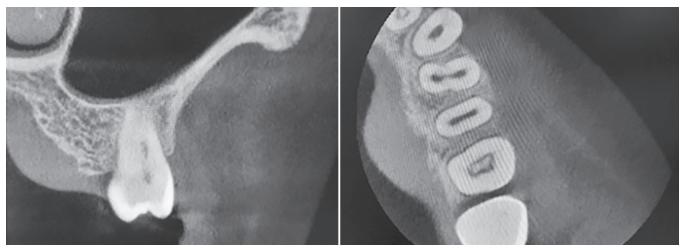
Cone-beam computed tomography showing no bony involvement with minor erosion
